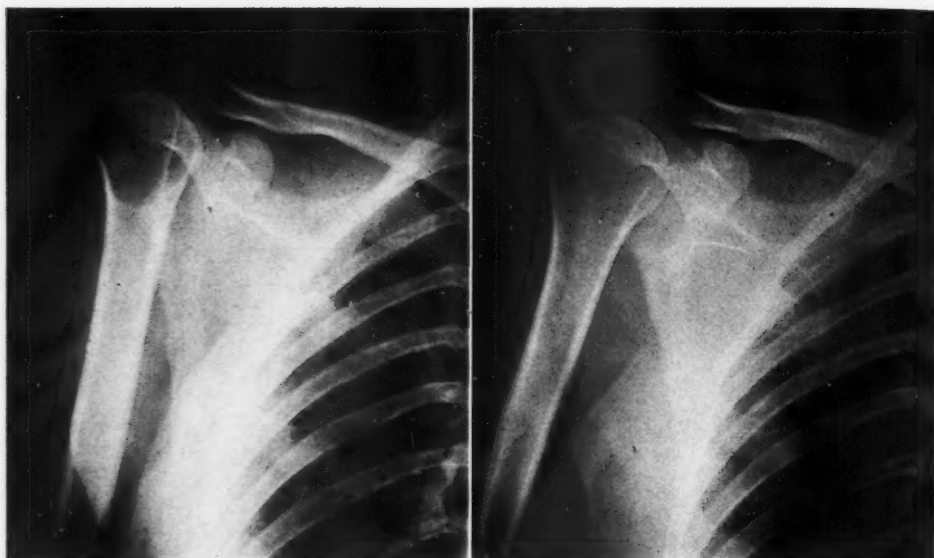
Case 4. M. K., No. 69,917, female, 33 years of age, was admitted to the Strong Memorial Hospital on Feb. 2, 1933, complaining of pain in the right shoulder. Six years previously she began to have severe aching pain in the right shoulder and right side of the neck, not relieved by treatment. There was no history of focal infection or trouble with other joints. On examination she showed atrophy of the right supraspinatus, infraspinatus, and deltoid muscles. There was point tenderness at the tip of the acromion process. Motion of the right shoulder showed good range but was slightly painful. Roentgen-ray examination of the humerus showed what appeared to be a large bone cyst in the head of the humerus. There was a calcified spot in the region of the subdeltoid bursa. In another view the cyst-like area did not show well but there appeared to be a loss of density of the greater tuberosity and the calcified areas in the bursa were more pronounced.
